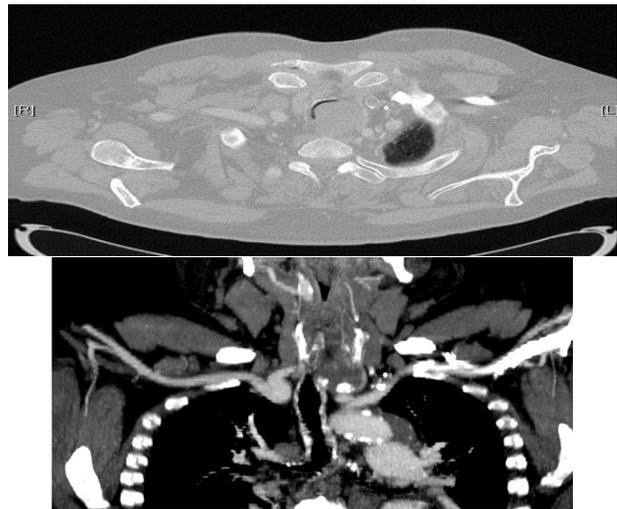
CT Scan Showed the Tumor in Axial and Coronal Planes
